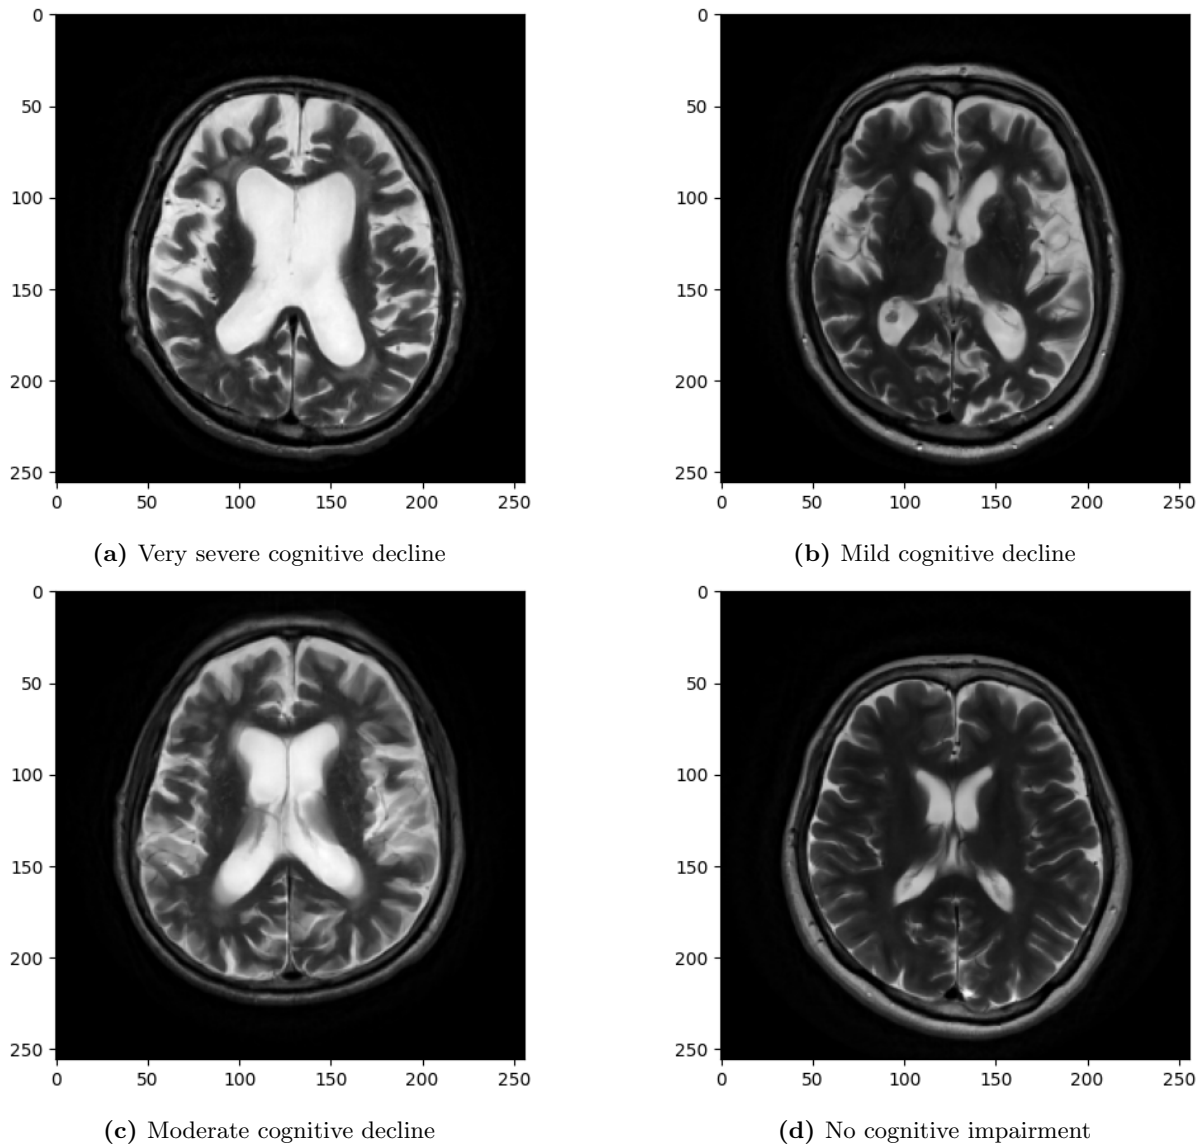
Sample T2-weighted images for some patients examined by Aydın Adnan Menderes University.
